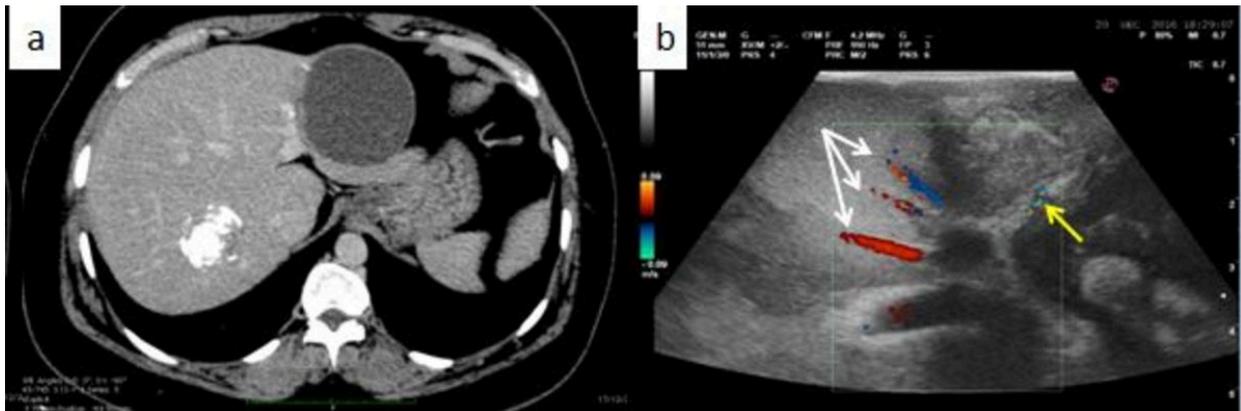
a- Hydatid cyst of the left liver compressing the vascular pedicles in CT-scan. b- IOUS allowed the visualization of the vascular pedicles of segment 2 (yellow arrow) and segment 4 (white arrows) from either side of the cyst.
